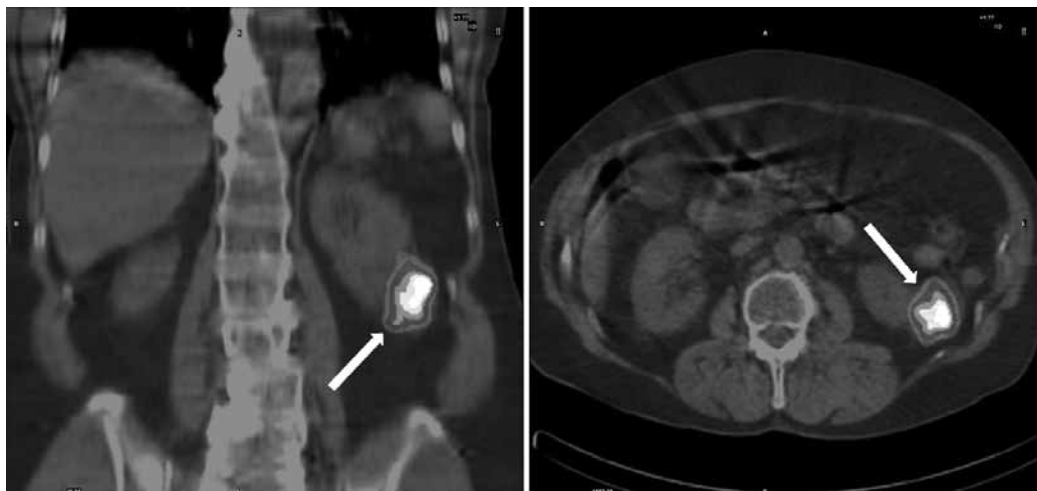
SPECT/CT images that revealed focal uptake at the posterolateral part of the left kidney with size $39 \times 35 \times 47$ mm
